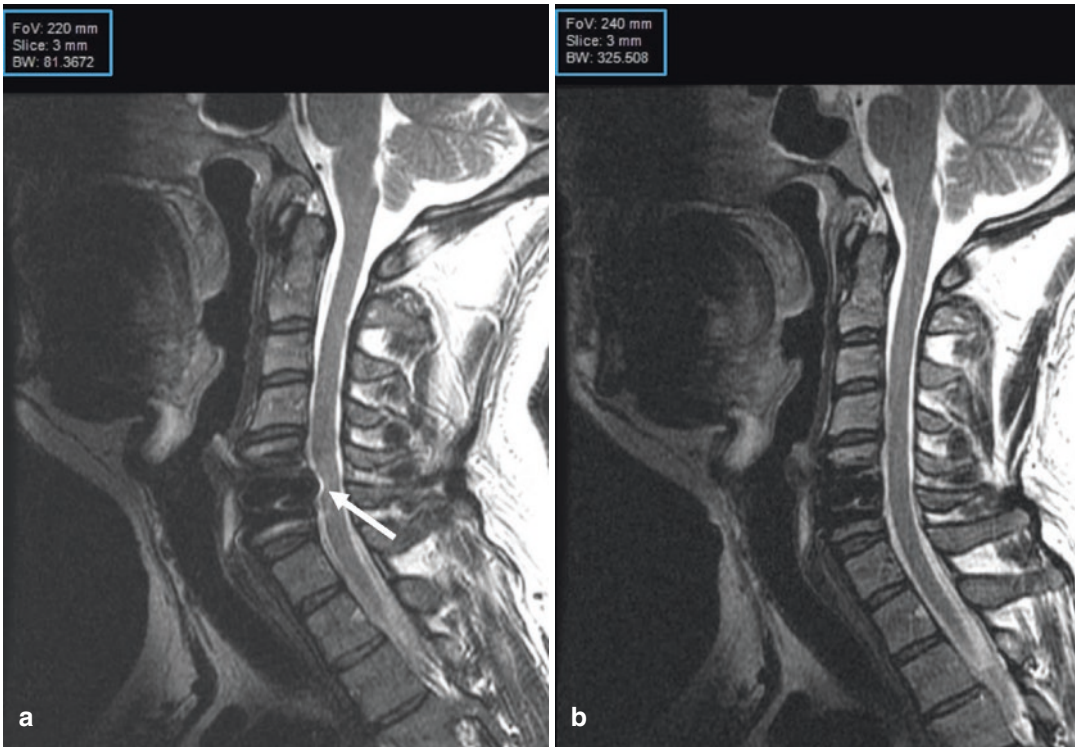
A 36-year-old male with neck pain radiating to the left arm 4 months post anterior cervical discectomy and fusion (ACDF) at C5–6. Sagittal T2-weighted image (a) using an 81 kHz bandwidth (blue box) demonstrates
